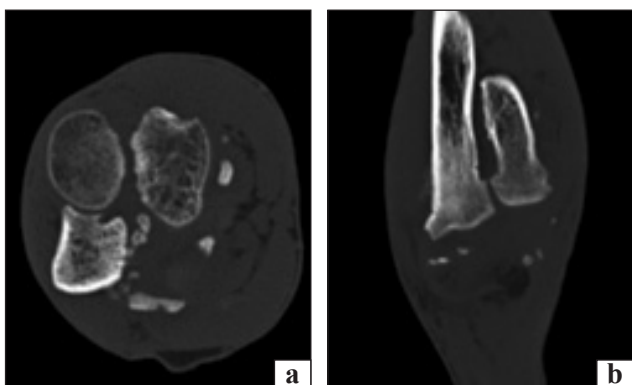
Horizontal (a) and frontal (b) CT sections at the level of the proximal radioulnar joint
